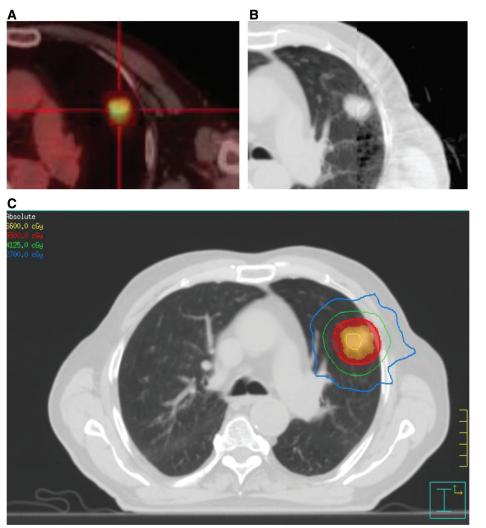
90-year-old man with severe COPD (GOLD III) presents with a biopsy-proven left lung cancer, treated with stereotactic radiotherapy (54 Gy in three fractions). Representative axial images correspond to: *A*, PET/CT. *B*, Patient setup, with ConeBeam CT matched to planning CT to confirm setup accuracy. *C*, SABR treatment plan. COPD, chronic obstructive pulmonary disease; PET, positron emission tomography; CT, computed tomography; SABR, stereotactic ablative radiotherapy.
